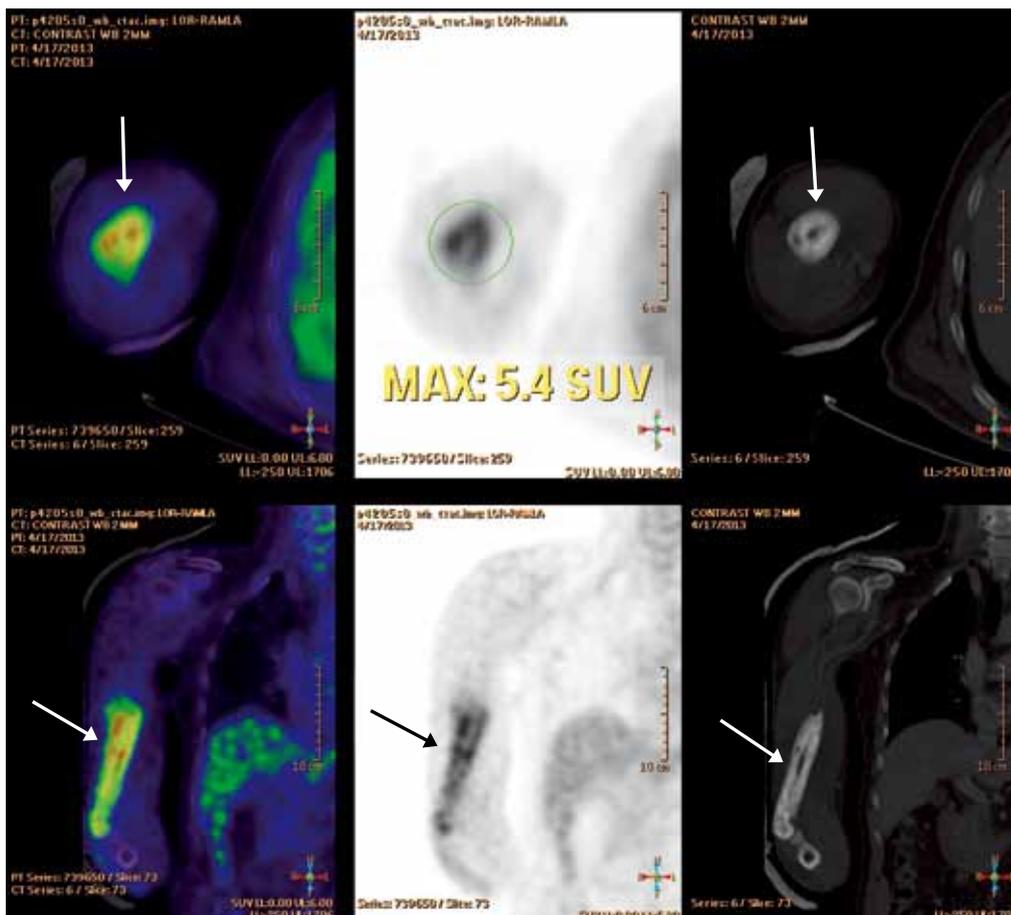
Positron emission tomography-computed tomography shows slightly elevated ^{18}F -fluorodeoxyglucose uptake distal to the fracture site (arrows). There is no associated soft tissue mass.
